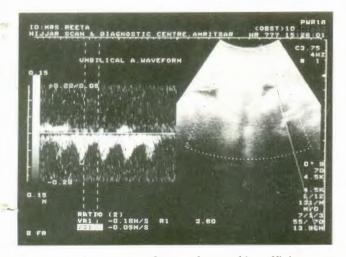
USG showing moderate placental insufficiency on colour Doppler study
